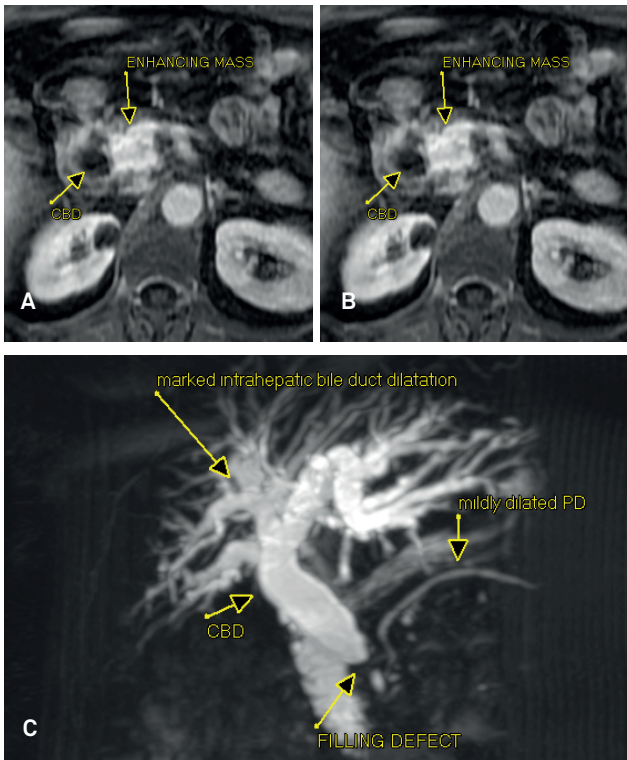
CE MRI of upper abdomen axial plane (a, b, d), tumoral mass lesion head of pancreas extracapsular. MRCP (d) dilatation of the bile ductus pronounced proximal intrahepatic and liver. DCB obstruction distal level.
